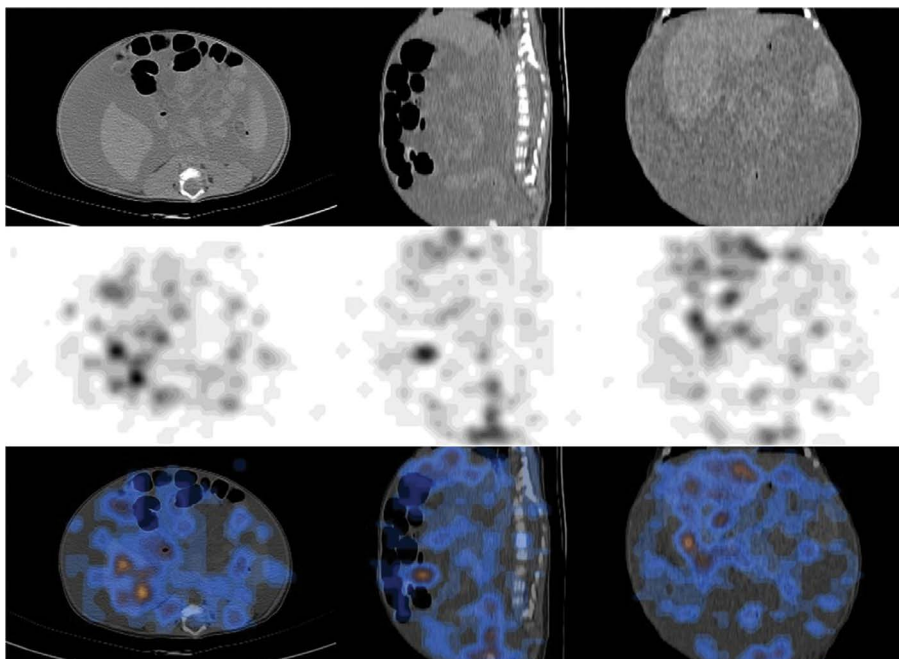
Computed tomography (CT) scan (top row); SPECT images (middle row) and single photon emission computed tomography/computed tomography SPECT/CT images (bottom row) in axial, sagittal, and coronal views confirmed the presence of activity in the peritoneal cavity
